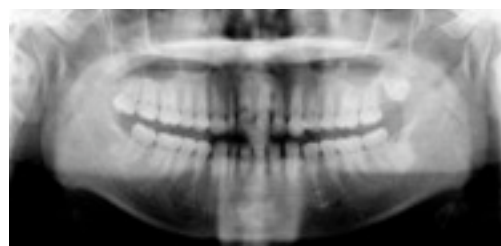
Pre-treatment panoramic X-ray showed nothing particular except the existence of two upper wisdom teeth. (Artifact on right anterior region was noted.)
